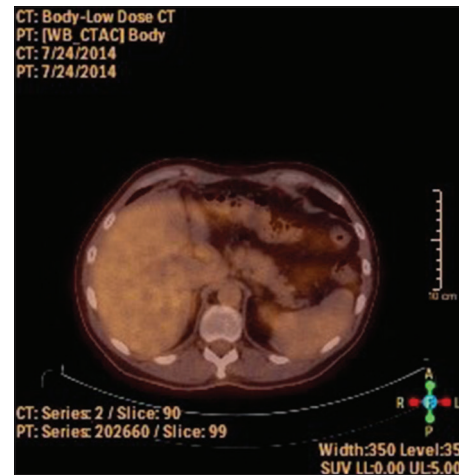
Computed tomography-positron emission tomography image at the level of pancreas did not reveal any increased activity
